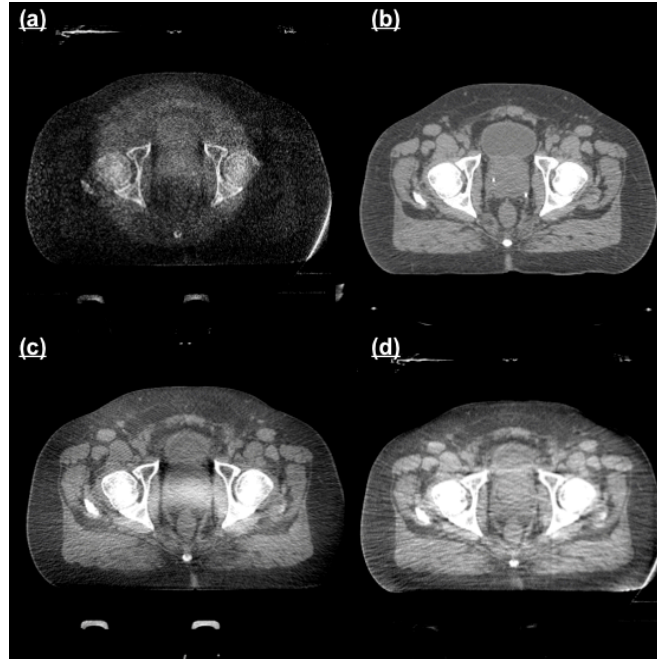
Second example of successful shading corrected axial CBCT images (Patient B) amongst 20 sets of total sample size.
